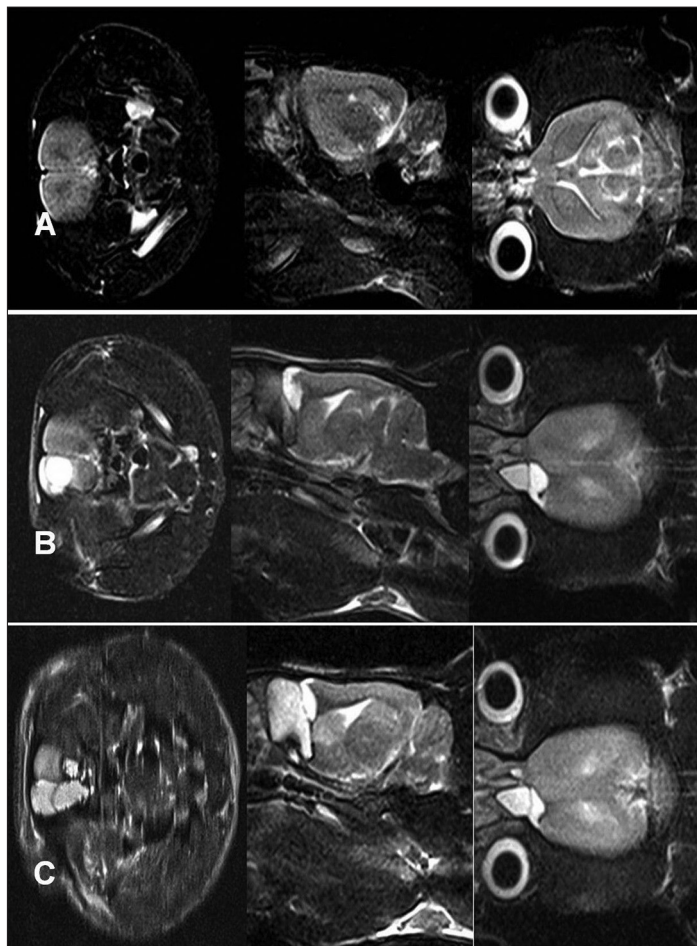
Following irradiation with dose of 70 Gy T2 weighted MRI images revealed no changes at 2 month (A), while cystic necrosis of frontal lobes were detected at 4 month (B) and 6 month (C)
